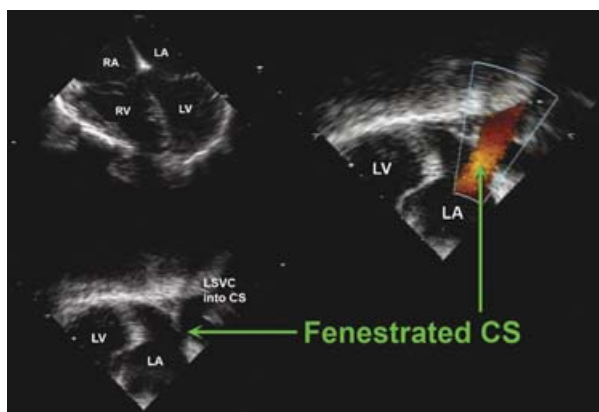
Transoesophageal echocardiography of a fenestrated coronary sinus (FCS) with a solitary opening in the terminal portion of the coronary sinus (CS) after previous surgery for ventricular septal defect in a 10-year-old boy with a cerebellar abscess due to paradoxical embolism in the presence of FCS. Upper left, The 4-chamber view shows only mildly enlarged right-sided cavities. Lower left, Large CS is shown due to the left superior caval vein (LSVC) draining into the CS. The arrow indicates the FCS. Right, The connection between the large CS and the left atrium (LA) via the FCS is visible with colour Doppler (arrow). LV: left ventricle; RA: right atrium; RV: right ventricle.
